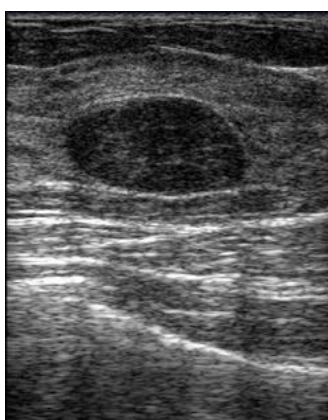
shows ultrasound of breast
